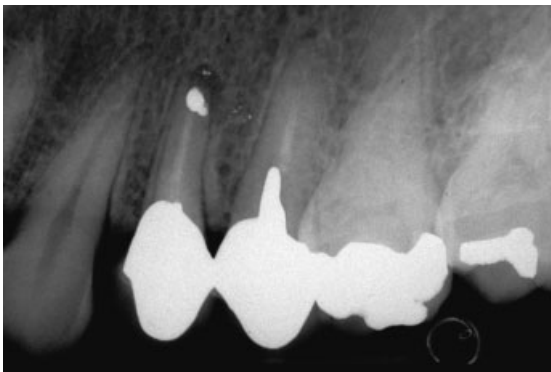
A periapical radiolucency on an upper premolar to be retreated.
